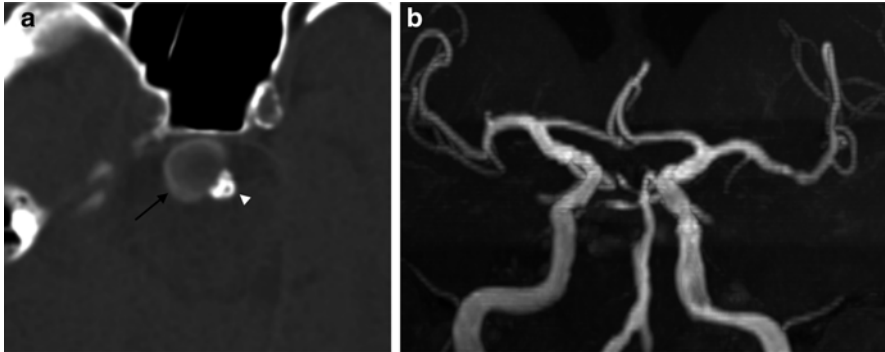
Basilar artery dissection. (a) Unenhanced axial CT image shows densely calcified atherosclerotic involvement of the basilar artery (*arrowhead*) with a partially thrombosed dissecting aneurysm sac (*arrow*). (b) Coronal MIP from TOF MRA. The aneurysm sac is poorly shown, but the basilar artery is moderately stenosed at the site of the dissection, and there is widespread vascular irregularity consistent with diffuse atherosclerosis
